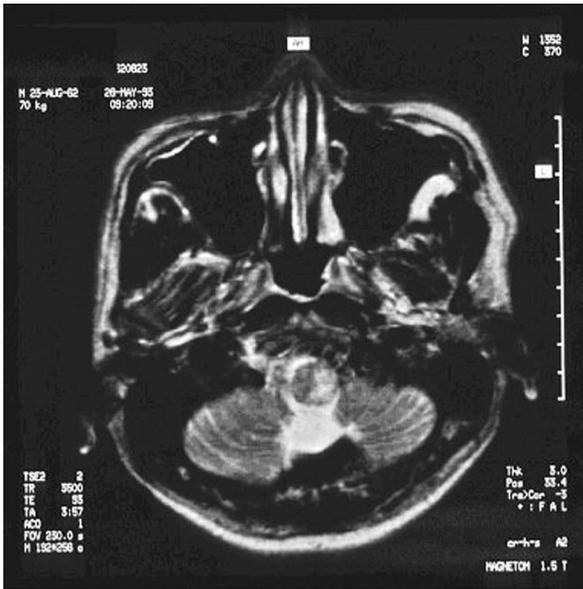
Left hemimedullary infarction (MRI T2-weighted image).
